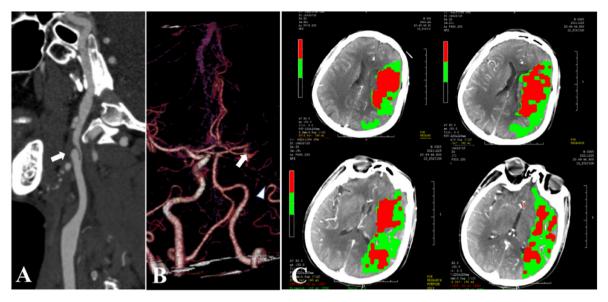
A: Cervical CTA (February 23, 2021) showed left ICA dissection (arrow); B left ICA (white triangle) and MCA (white arrow) occlusions in Cervical CTA (February 25, 2021); C: left cerebral perfusion was impaired in CTP (February 25, 2021).
